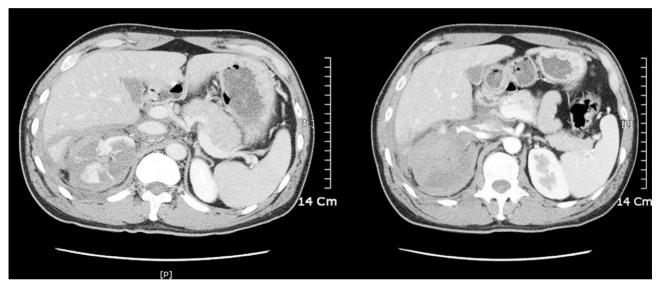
Initial CT scan shows right renal injury with massive hemorrhage at intrarenal, perirenal, and pararenal spaces, and liver injury with small amount hemoperitoneum at perihepatic space.
